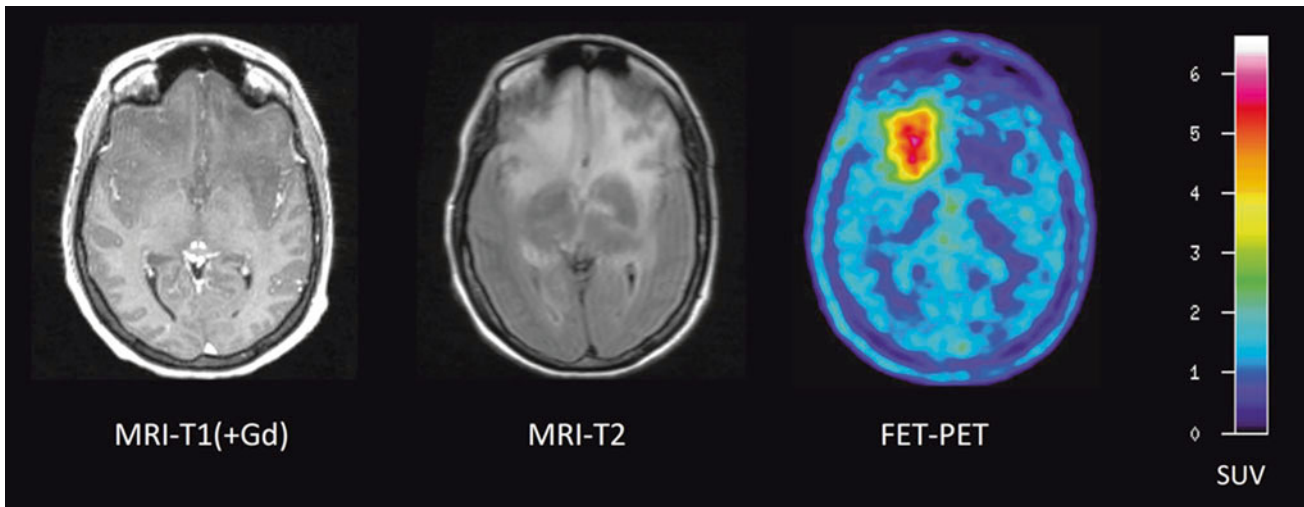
Patient with an astrocytoma of WHO grade II in the frontal lobe. T1-weighted MRI after application of Gd-DTPA shows no pathological contrast enhancement and the tumor cannot be delineated.
